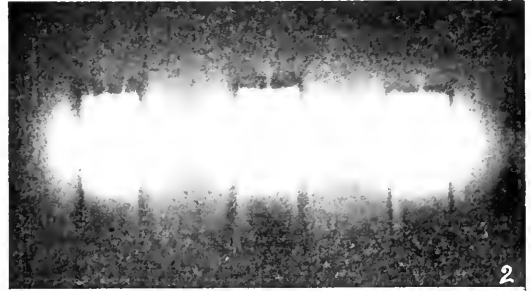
THREE TUBES RADIUM ELEMENT, 25 MILLIGRAMS EACH, CONTAINED IN ORIGINAL SILVER TUBE, NO OTHER FILTER, PLACED OVER LEAD STRIPS ONE, TWO AND THREE MILLIMETERS THICK, RESPECTIVELY. ALL PLACED ON LIGHT PROOF PHOTOGRAPHIC NEGATIVE. EXPOSURE ONE HOUR. Note limit of visible radio-activity, also actinic shadows and secondary ray effects.
